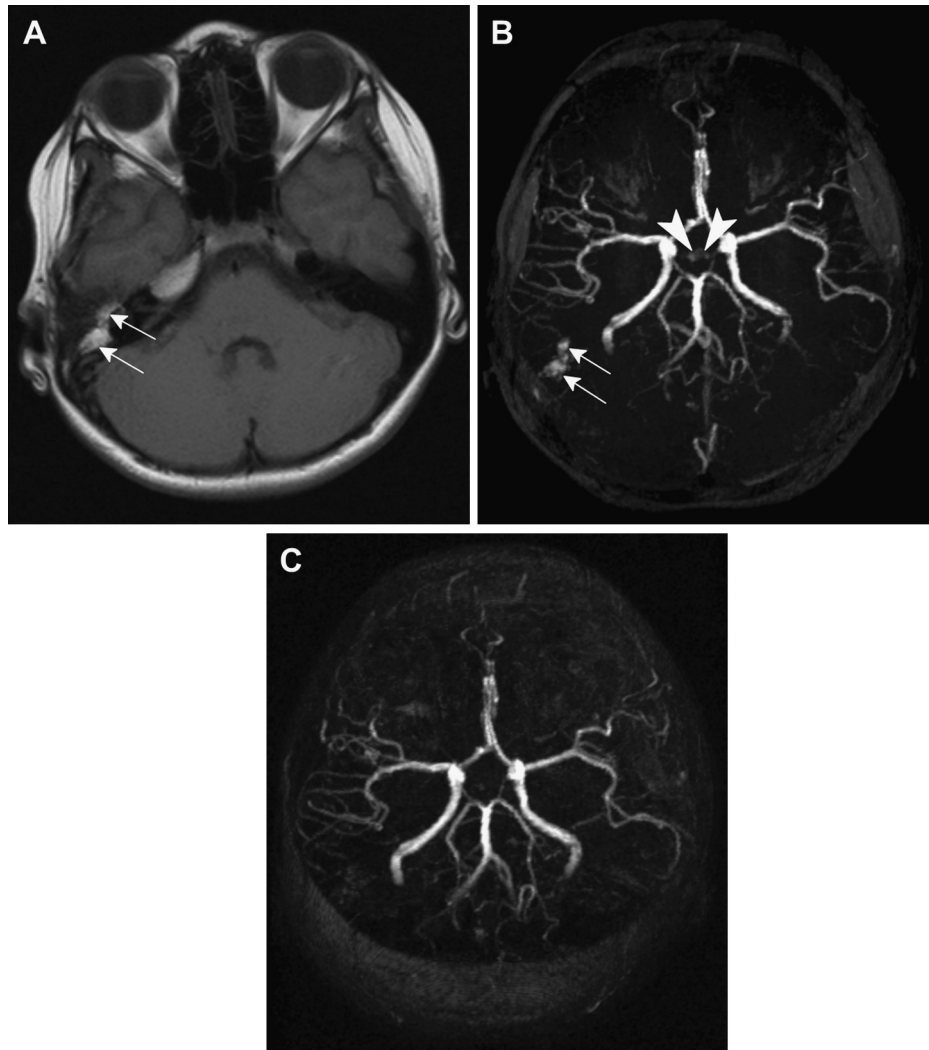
Cholesterol granuloma in a 13-year-old female who presented with right hearing loss for a long time. (A) Axial T1-weighted image through the cerebellopontine angles showing a dumbbell mass (arrows) with short T1 contents in the right middle-ear cavity and adjacent mastoid antrum. (B) Axial conventional three-dimensional (3D) time-of-flight magnetic resonance (TOF MR) angiogram showing a suspected vascular lesion (arrows) in the right temporal bone. The high signal intensity (SI) of the posterior pituitary lobe (arrowheads) can be visualized. (C) Axial subtraction 3D TOF MR angiogram showing no obvious vascular lesion. The suspected vascular lesion on the conventional MR angiogram (B) has disappeared, indicating that it was a tumor mass. The high SI of the posterior pituitary lobe was also removed by the subtraction method.
